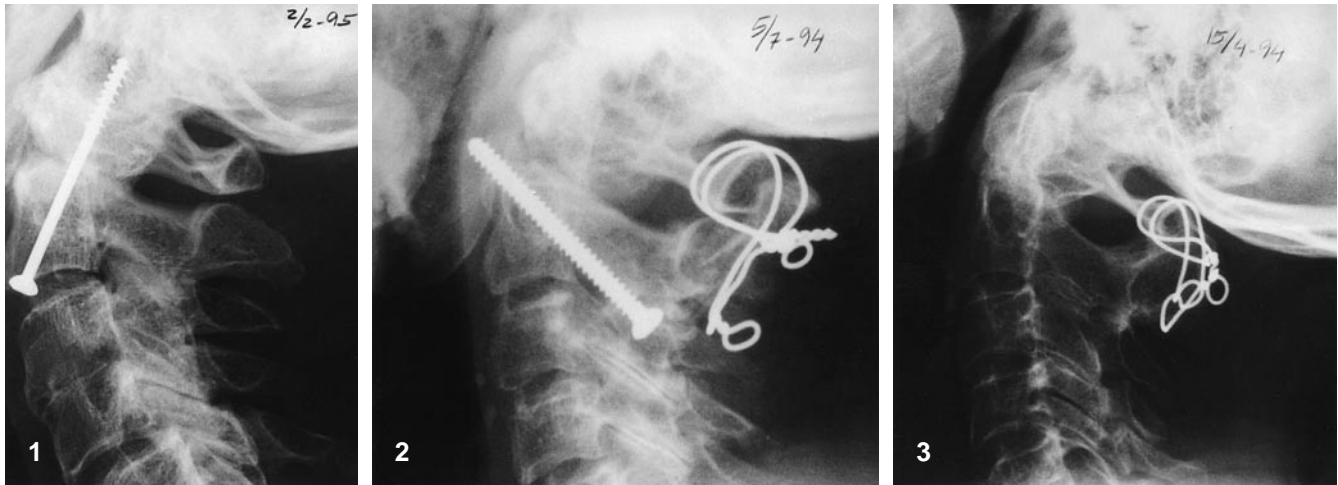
A follow-up radiograph of a patient with an Anderson and D'Alonzo type II fracture treated with direct screw repair with an obvious non-union
